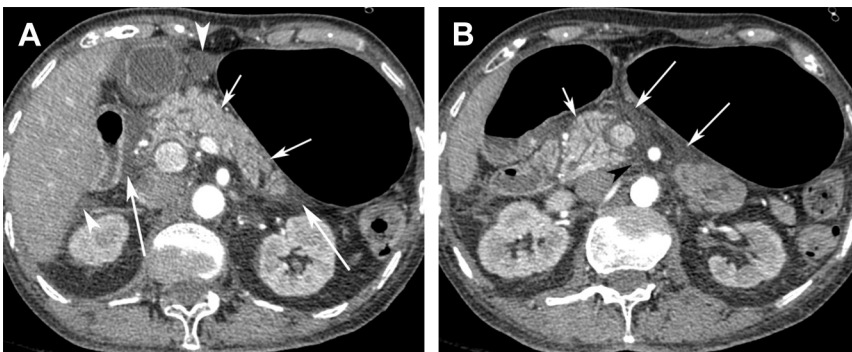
Edematous pancreas after overhydration. (A) The pancreas is swollen and edematous (short arrows) with fluid and stranding in the peripancreatic area and between duodenum and head of pancreas (long arrows) mimicking acute pancreatitis. Ascites (arrowheads) is seen in Morrison pouch and surrounding the thick-walled gallbladder. (B) Same patient as Fig. 19A. Edema is shown in the head of pancreas (short white arrow) on this axial CT image with stranding and fluid in the lesser sac (long white arrows) and surrounding the superior mesenteric artery (black arrowhead), typically seen in excessive hydration.
